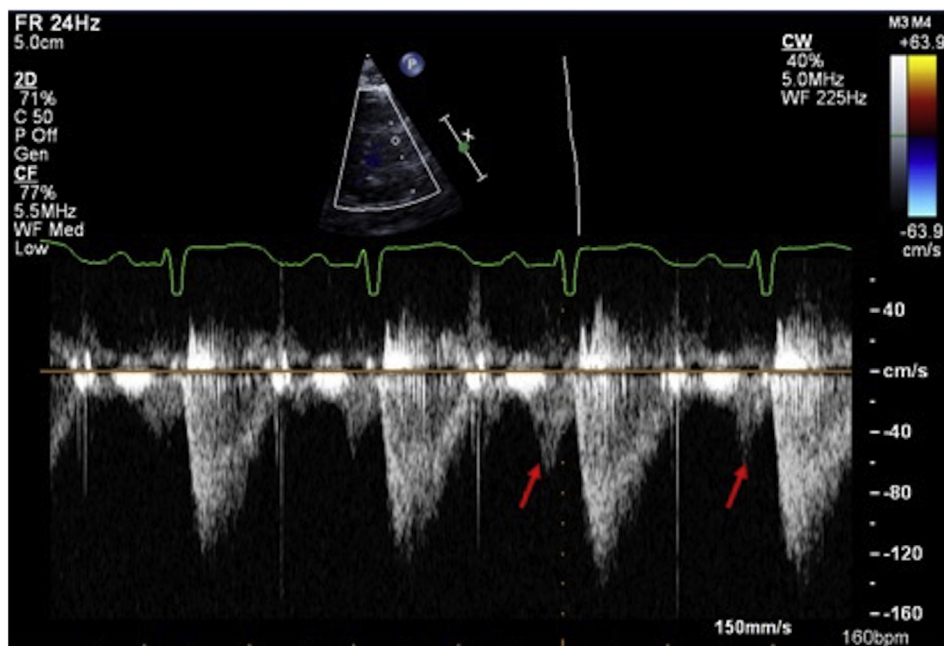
Right end-diastolic forward flow by echocardiography.⁸⁷ Restrictive physiology of the right ventricle can be assessed by pulse wave Doppler of the main pulmonary artery mid-way between the pulmonary valve and pulmonary artery bifurcation. A restrictive right ventricular has antegrade end-diastolic flow in the MPA from atrial contraction (arrow).
